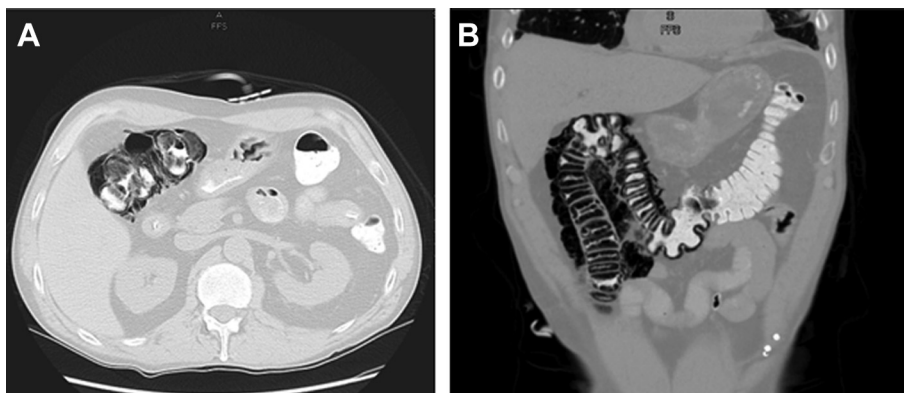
Abdominal CT scan (day 0) with coronal (A) and sagittal (B) views.
